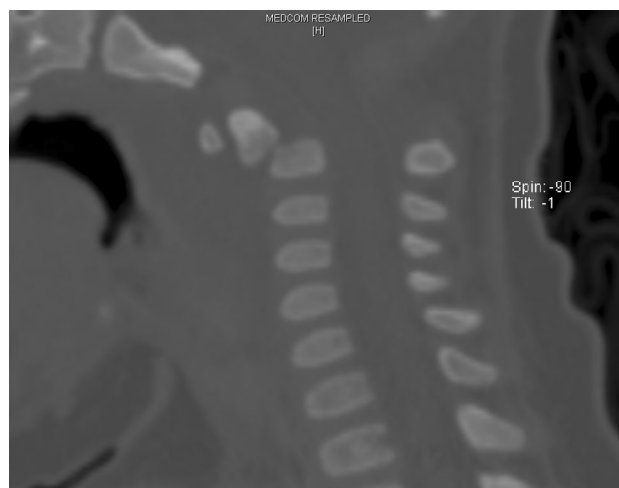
The computed tomography sagittal image reveals retropharyngeal swelling and destruction of odontoid synchondrosis with atlantoaxial subluxation
